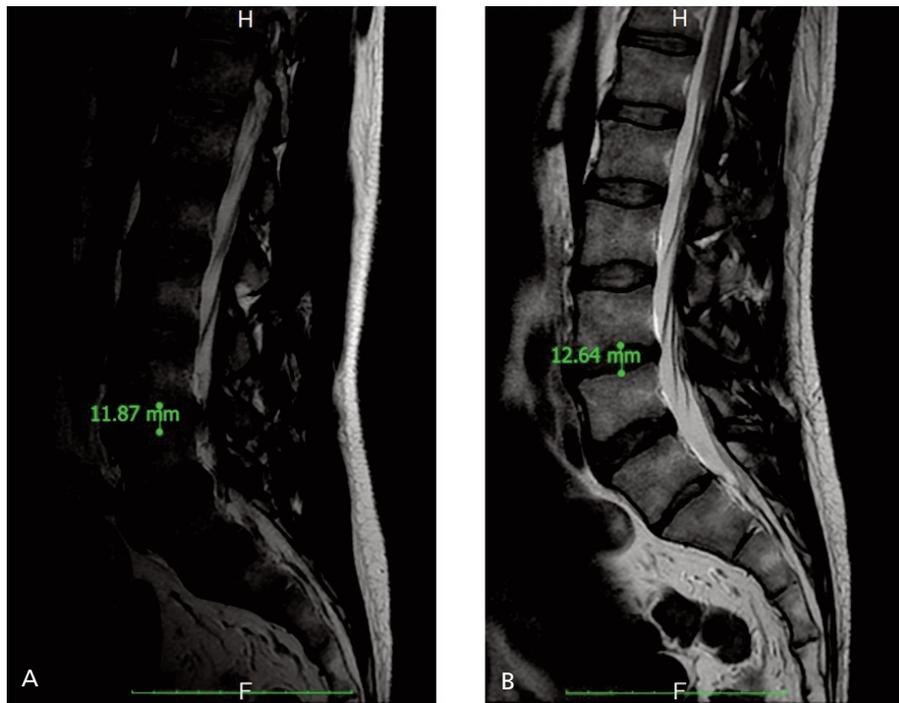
A*, Pre-surgical sagittal T2-weighted MRI showing disc protrusion at L3-L4. *B*, Post-operative sagittal T2-weighted MRI. Note the consistent improvement of protrusion and the residual discal bulging, with increased intervertebral disc height, compared to preoperative images.
